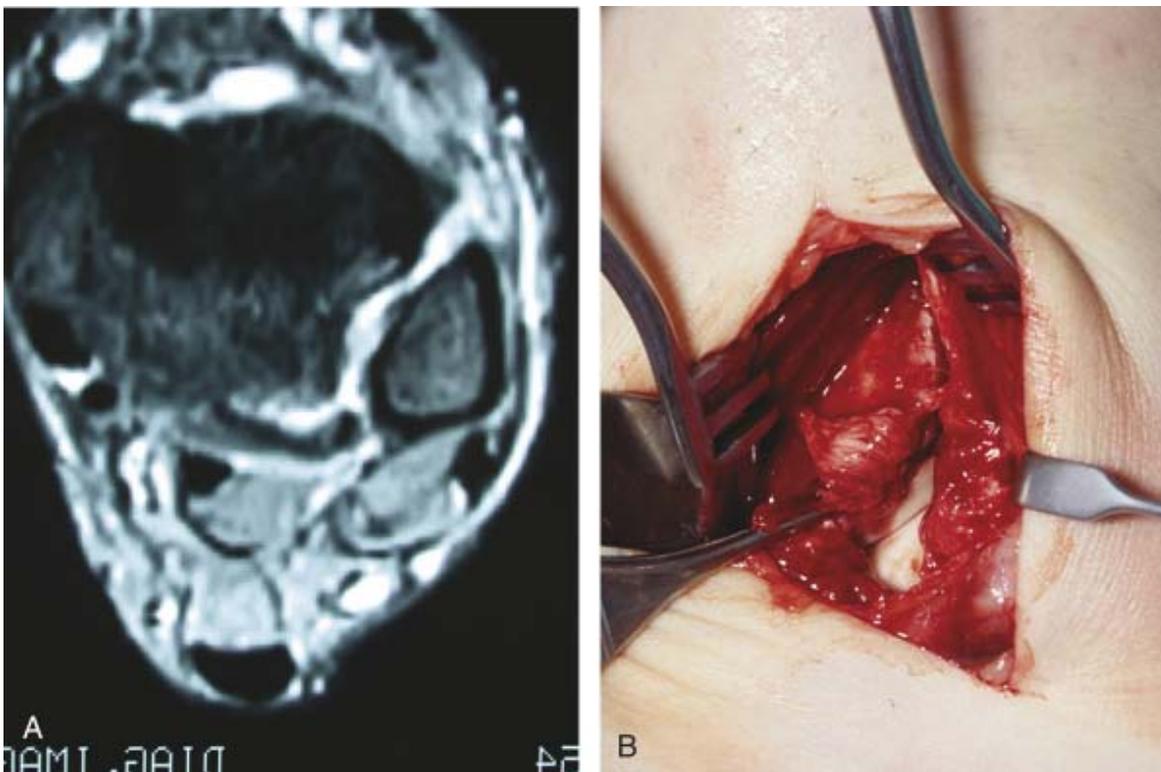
Figure 25C1-37 A, Magnetic resonance image demonstrating complete tear of AITFL and partial tear of PITFL. B, Open treatment of syndesmotic rupture.
